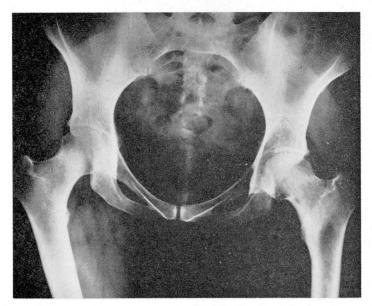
(Case 1) Preoperative roentgenogram of pelvis. On the right there is a small radiolucent area along the inferior aspect of the femoral neck with some sclerosis of bone extending down to the lesser trochanter.
